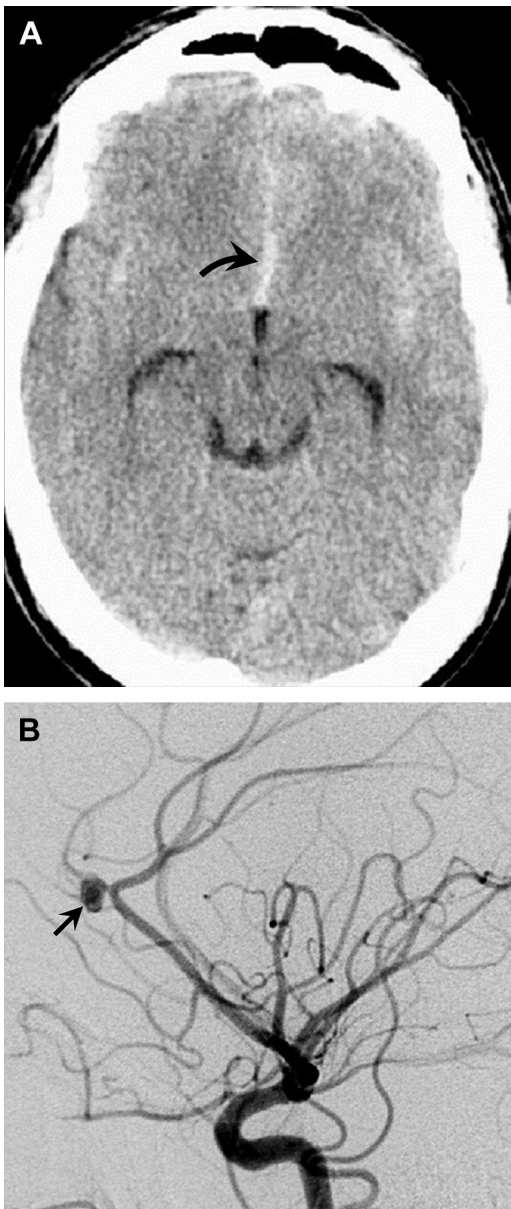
Traumatic pericallosal aneurysm. (A) Axial CT images demonstrate extensive posttraumatic subarachnoid hemorrhage within the anterior interhemispheric fissure (*curved arrow*), greater than expected considering the degree of the patients' other intracranial injuries. A high index of suspicion for traumatic CVI is indicated and additional workup is needed. (B) Lateral angiogram depicts a traumatic pericallosal aneurysm (*arrow*). Posttraumatic aneurysms in this location likely result from partial avulsion of cortical arterial branches from the pericallosal artery due to excessive shift of the frontal lobes in relation to the more fixed corpus callosum.
